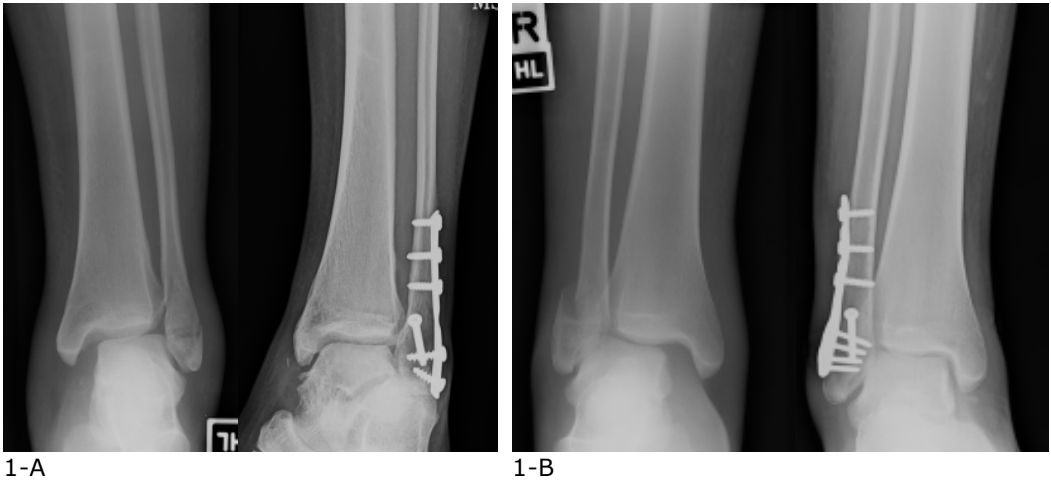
Preoperative and 12 week postoperative anteroposterior mortise ankle radiographs of similar lateral malleolar fractures. Both with a single interfragmentary lag screw, and neutralization plates of comparable lengths. A, treated with conventional one-third tubular plate. B, treated with contoured distal fibular locking plate and locking distal fragment screws.
